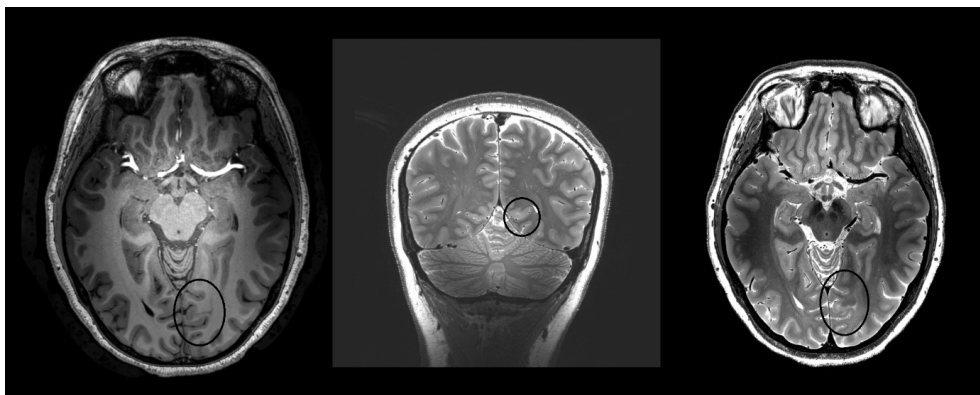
Focal cortical dysplasia at 7T MRI. Focal cortical dysplasia demonstrated on axial T1-weighted images (left), coronal T2-weighted images (middle), and axial FLAIR images (right). Subtle cortical thickening and blurring of the gray–white matter junction are best appreciated on the T2-weighted and FLAIR images.
